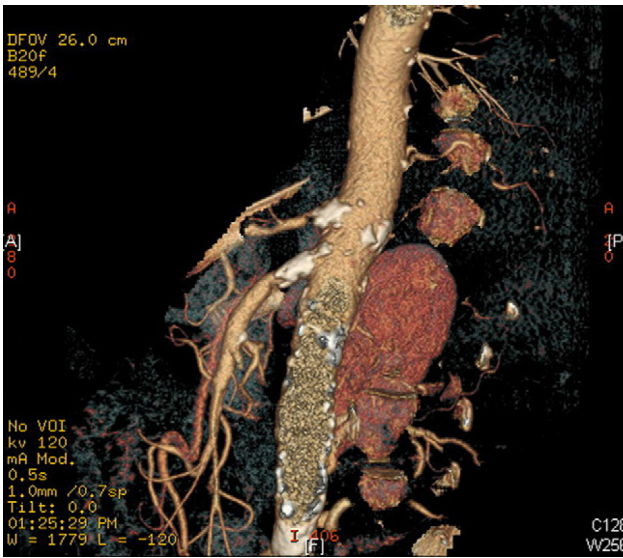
Contrast CTA of aorta with reconstruction, demonstrating marked atherosclerosis at SMA and coeliac axis origins.
